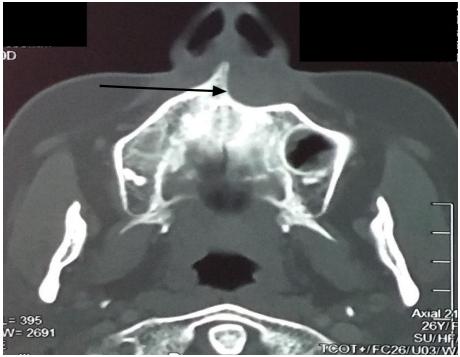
axialcomputed tomography-scan showing a nasolabial cyst with bony erosion (black arrow)
